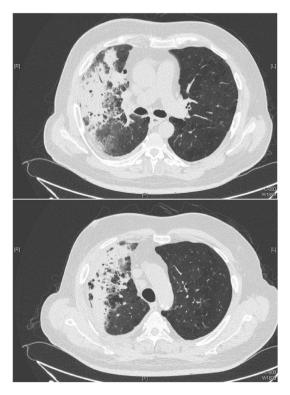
Chest CT at presentation showing a large right upper lobe alveolar infiltrate with air bronchogram.
